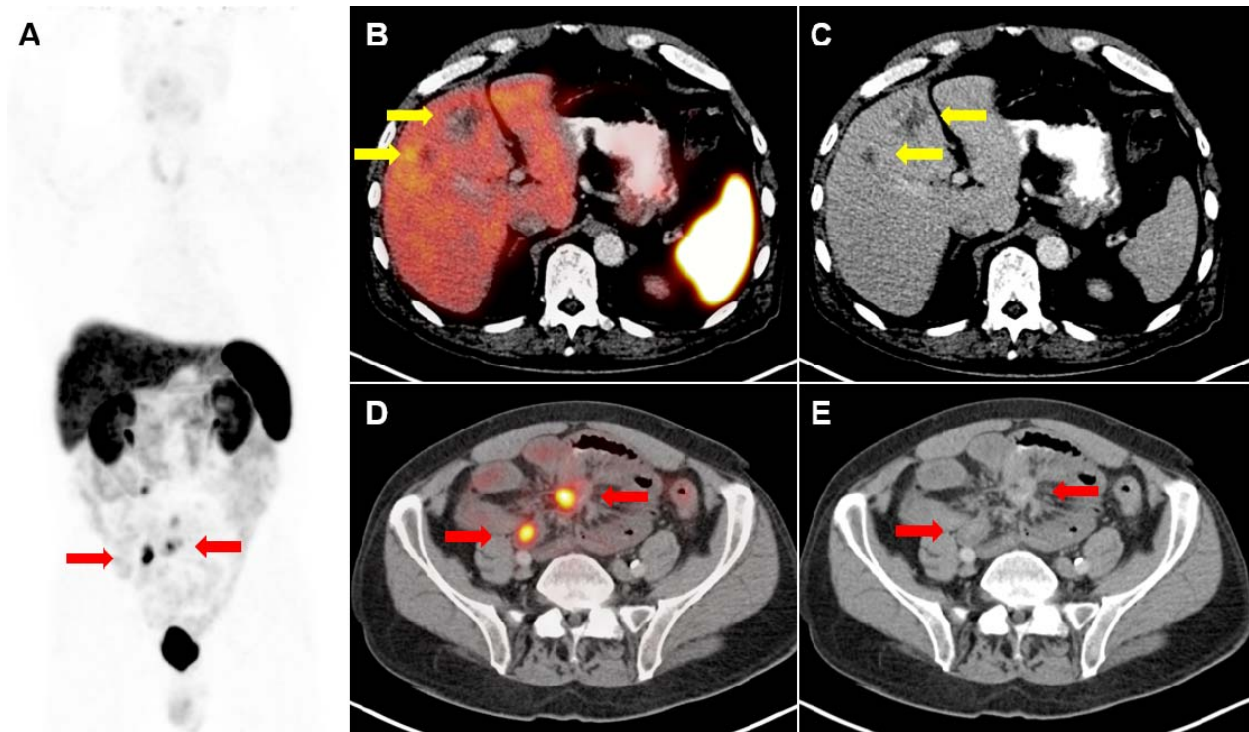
Example of a 62-year-old male referred for initial staging of metastatic small bowel low grade NET. CT and MRI showed mesenteric mass, enlarged abdominal lymph nodes and equivocal liver lesions (hemangiomas vs metastases). He has had prior slightly increased 24h urine 5-HIAA supporting the suspicion of hepatic metastases. The referring physician indicated in Q1 he was considered for octreotide. ^{68}Ga -DOTATATE PET/CT ruled out hepatic metastasis (yellow arrows), confirmed mesenteric primary site and lymph node involvement (red arrows), as seen on ^{68}Ga -DOTATATE PET MIP (A), fused ^{68}Ga -DOTATATE PET/CT axial views (B,D) and corresponding CT axial views (C,E). In Q2, the referring physician indicated an intended management change toward surgery which was confirmed later in Q3. The patient finally underwent resection of small bowel NET with wide margins. Follow-up MRI and urinary carcinoid biomarker showed no disease recurrence.
